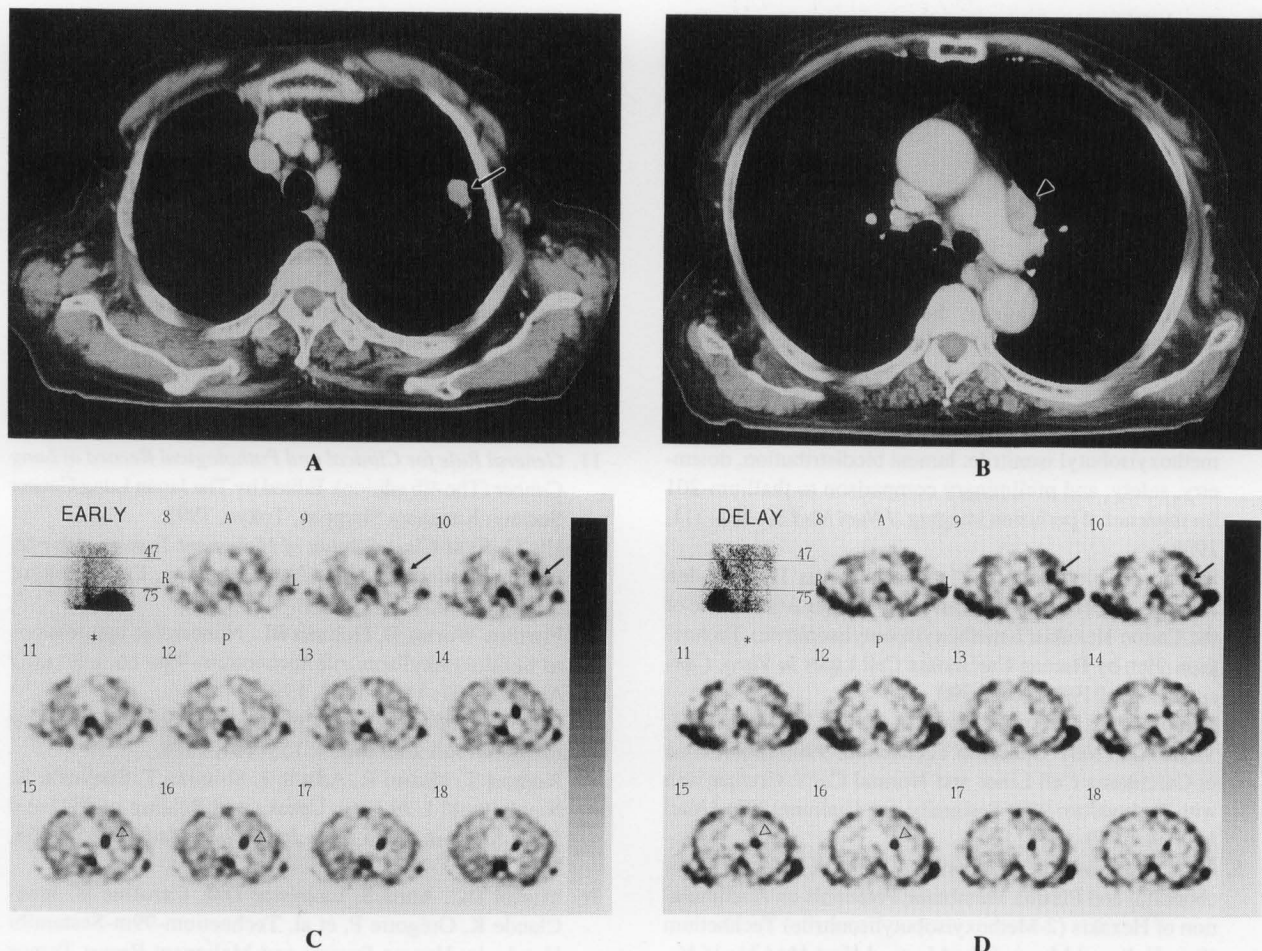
A 71-year-old woman with adenocarcinoma at the left S¹⁺² (1.5 × 1.0 cm) and an enlarged subaortic arch lymph node (2.2 × 1.5 cm) (pT1N2M0). Chest CT (A, B) shows a solitary nodule in the left S¹⁺² (arrow) and an enlarged subaortic arch lymph node (arrowhead). Early transverse images of Tc-99m MIBI SPECT (C) abnormal uptake in the areas corresponding to the lesion (arrow) and subaortic arch lymph node (arrowhead). On the delayed images (D), the accumulation at the tumor (arrow) and subaortic arch lymph node (arrowhead) has not been washed out.
